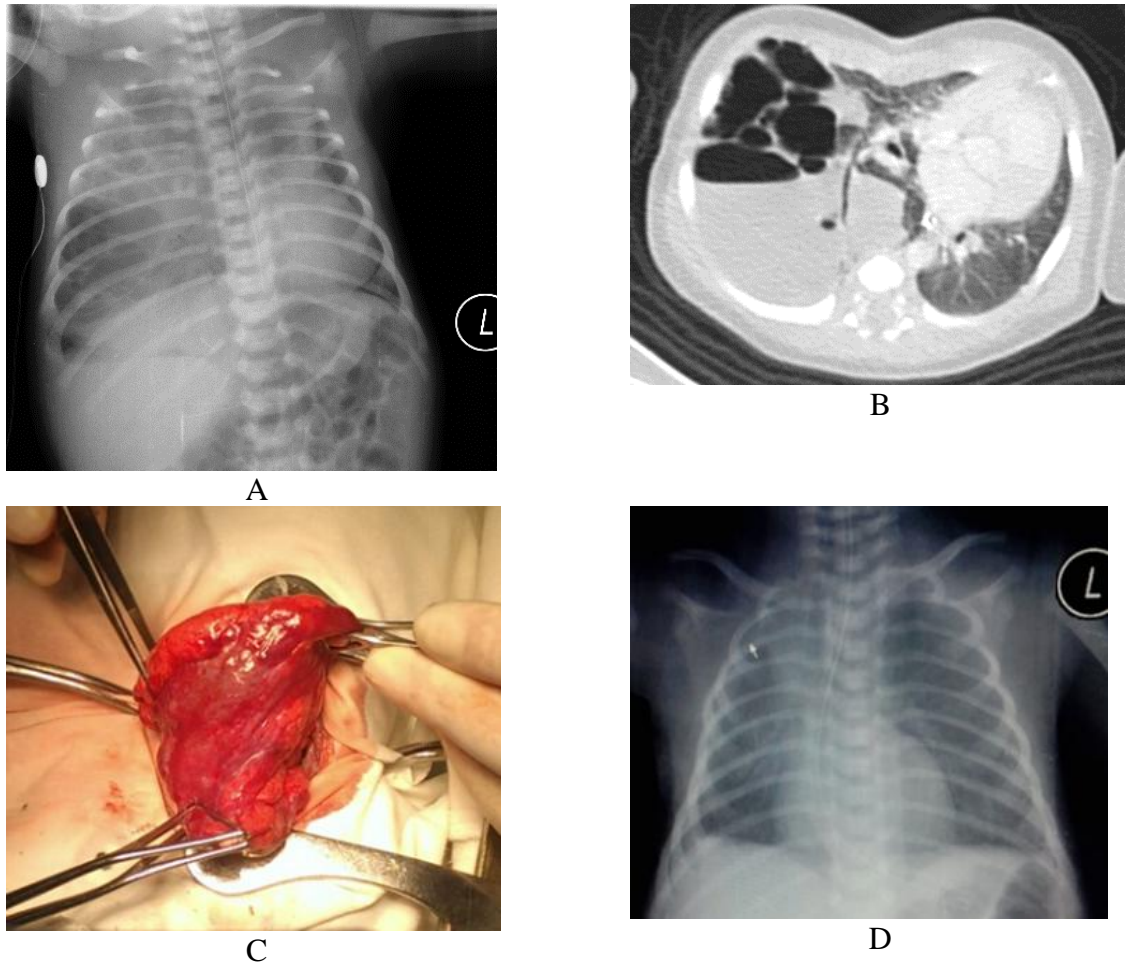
Diagnostic tests and operational photo of newborn baby with tension polycystic lower lobe of the right lung. A – plain chest radiograph (age 3 days): the right lung is of increased volume, hyperinflated, has multiple cellular foci transparency, forms mediastinal hernia; mediastinum is shifted to the left. B – CT with contrast enhancement (age 4 days), axial scan at the level of s6 bronchus branching (arrow): multiple cavities in right lower lobe partially filled with fluid. C – operative photo: right lower lobe with multiple cysts and islets of normal parenchyma (age 6 days), operation – right lower lobectomy. D – plain chest radiograph 2 weeks after surgery: right upper and middle lobes expanded to fulfill the hemithorax, mediastinum is at near normal position.
